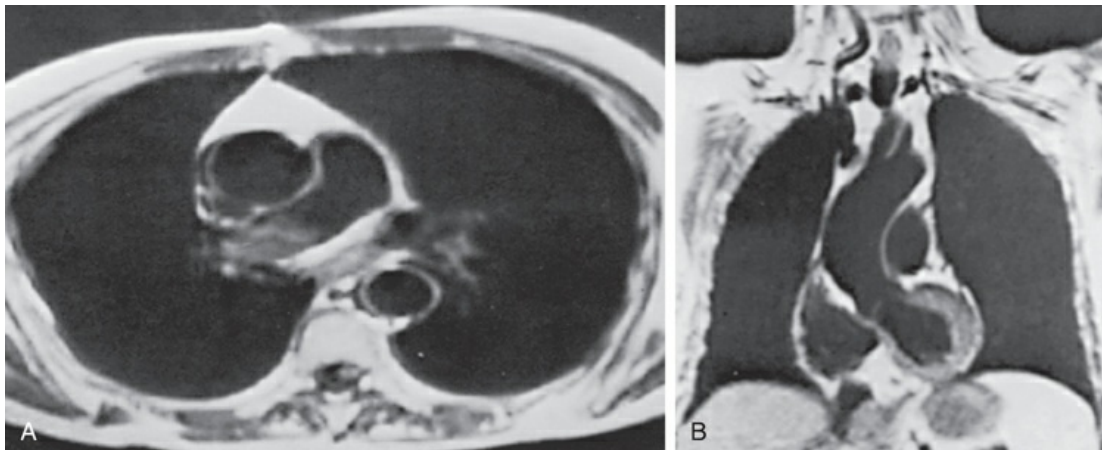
Magnetic resonance images of normal chest in cross-sectional (A) and coronal (B) views. Lumen of structures that contain blood appears black because flowing blood produces a signal void.
